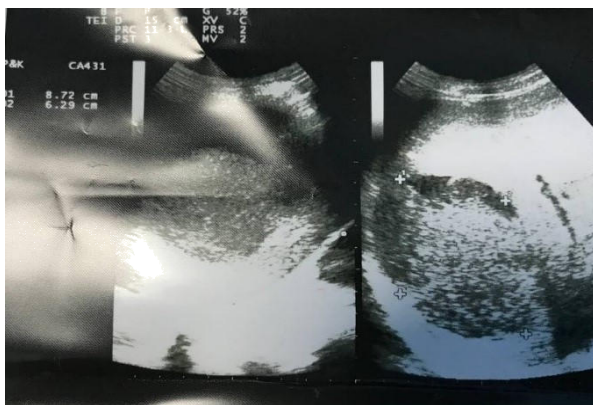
Liver ultrasound
